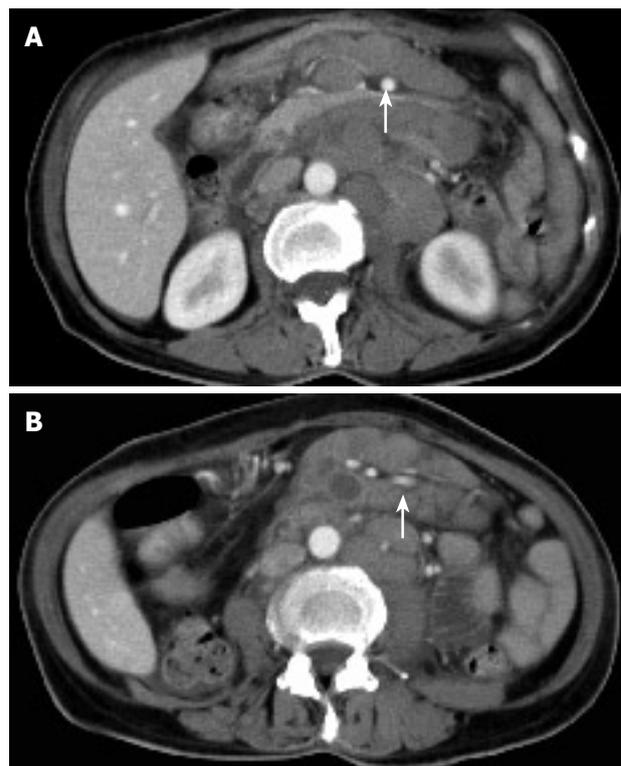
Contrast enhanced CT scan for a 56-year-old woman with NHL involving SBM showing enlarged lymph nodes in the root of SBM encasing the superior mesenteric artery (arrow), producing the "sandwich sign" (A) and homogeneously mixed peripheral enhancement of lymph nodes in the body of SBM encasing the small bowel mesenteric vessels (arrow), producing the "sandwich sign" (B).
